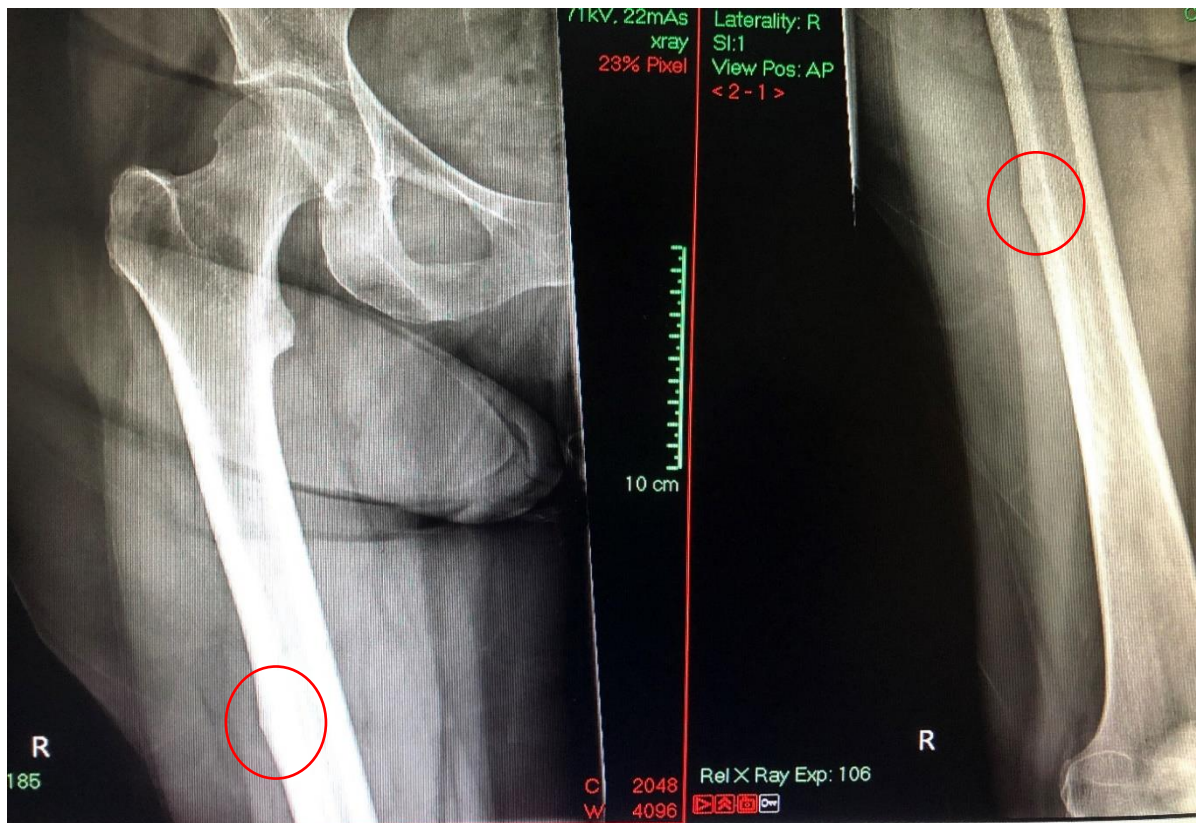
Radiographs of the right femur with lateral peak identified.
